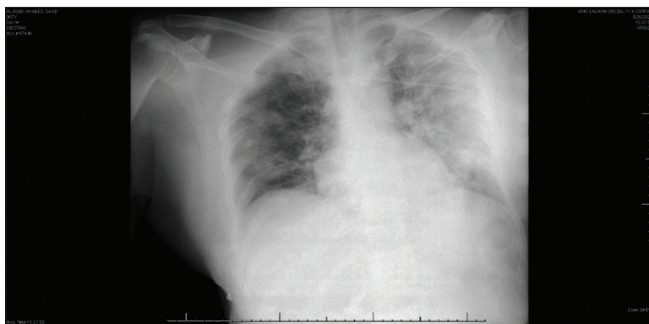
Chest X-ray of patient on day of admission to ICU
